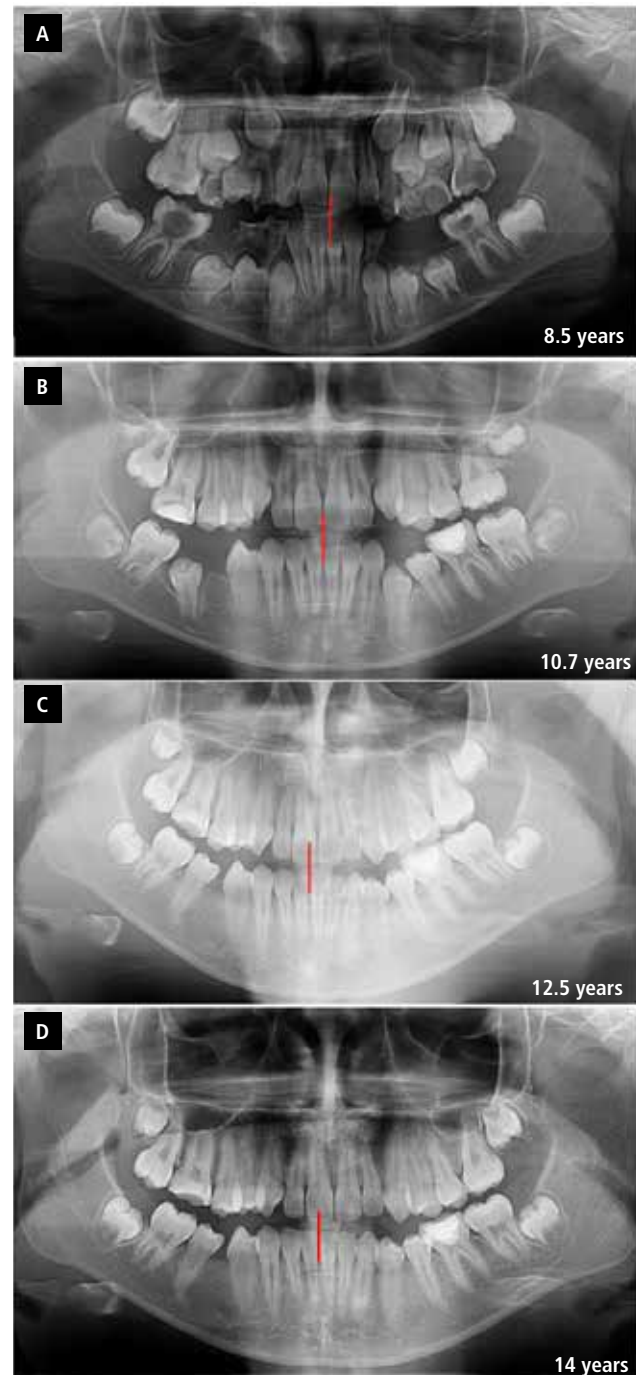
Panoramic radiographs of patient 2. a) Preextraction panoramic radiograph: teeth 26 and 46 were planned to be extracted. b) Control panoramic radiograph 2 years after extractions: successful closure of the extraction gap in the left side of the maxilla. c) Control panoramic radiograph 4 years after extractions. d) At the end of 5.5 years, the lower right second permanent molar and the second premolar came into contact, but diastema formed between the other teeth in the relevant quadrant, and the midline shifted to the extraction side.
